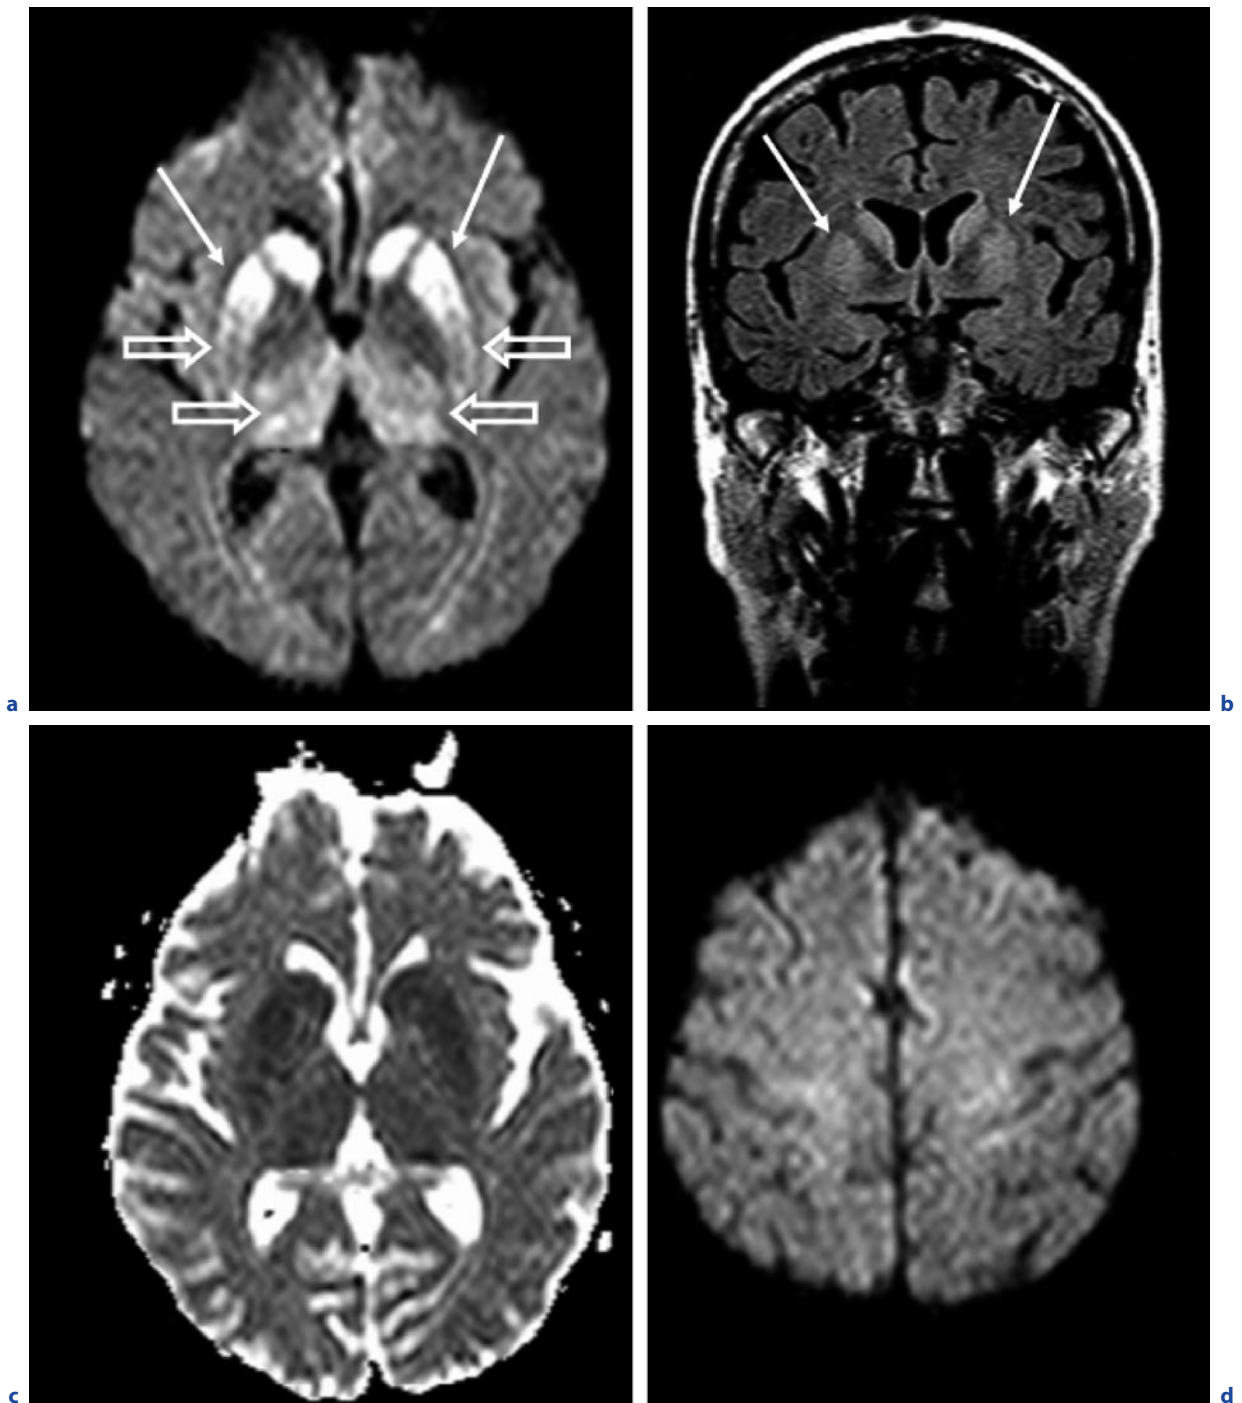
“Classic” sporadic Creutzfeldt-Jakob disease (sCJD). A 66-year-old woman with dementia and myoclonus rapidly progressive over 4 months. a Axial DWI at the level of the basal ganglia. b Coronal FLAIR image. c Axial ADC map. d Axial DWI at the level of the parietal cortex. Markedly increased signal intensity of the anterior putamen (arrows) and the head of the caudate nucleus on both sides on DWI (a).
